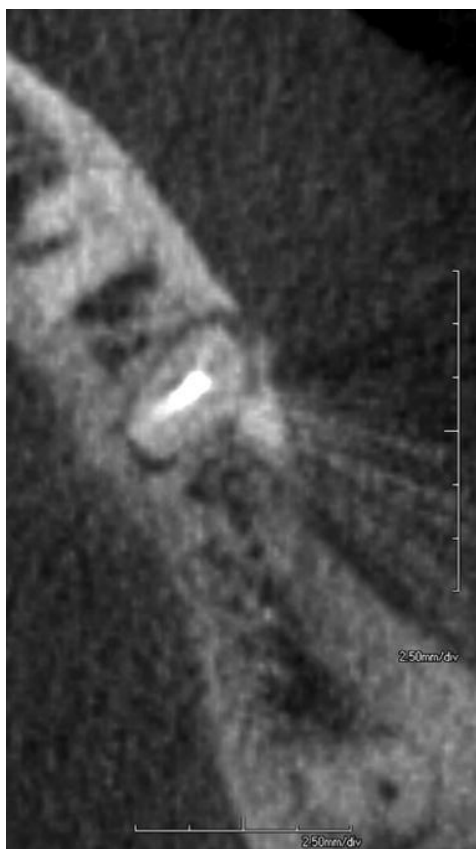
Low-dose coronal MCT image demonstrates a severe narrow palatal vertical periodontal defect associated with this root of tooth 16. This is likely related to a vertical root fracture. Undisplaced root fractures can be subresolution and not detected with MCT or CBCT. This palatal periodontal defect would not be detected on an intraoral radiograph. Note the adjacent reactive sclerosis, likely related to the chronic nature of the lesion.
